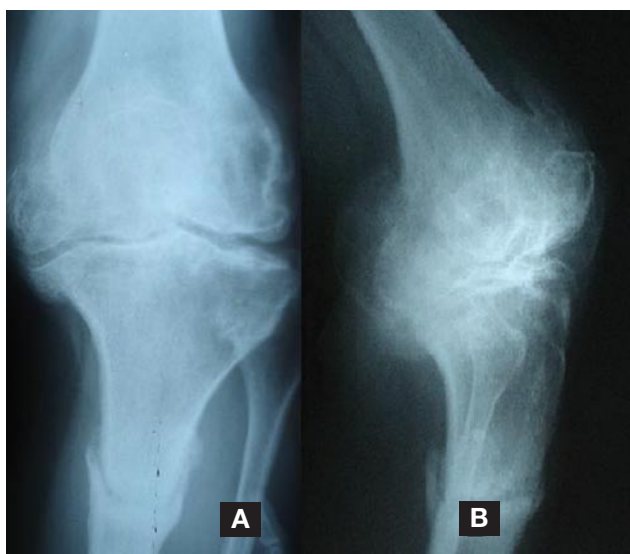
Case 1—preoperative anteroposterior (A) and lateral (B) radiographs.
